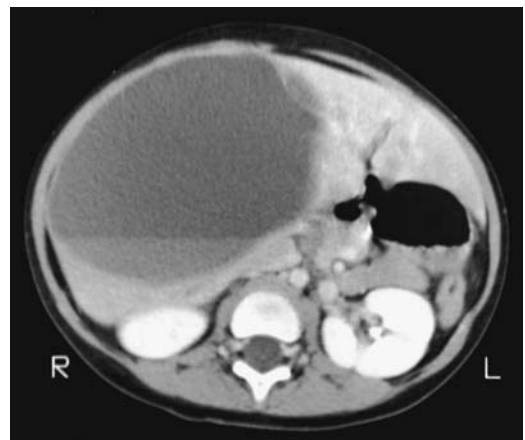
Undifferentiated embryonal sarcoma. Contrast-enhanced CT reveals a liver cyst-like tumor with a fluid–fluid level. These are mostly solid tumors, but due to their high water content CT often shows them to be of almost water density. (Courtesy of Luann Teschmacher, M.D., University of Rochester.)
